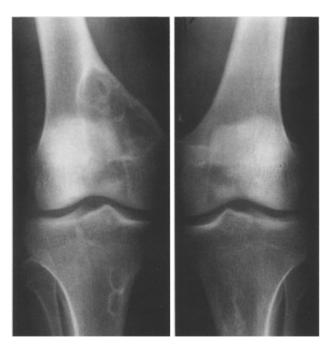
Anteroposterior (AP) radiograph of both knees demonstrates typical multiple skeletal fibroxanthomas – eccentric lytic lesions that are well-defined, have sclerotic margins of variable thickness, and are located in the metadiaphyseal regions of long bones of the lower extremities. There is a large fibroxanthoma in the distal right femur and relatively symmetric fibroxanthomas in the proximal contralateral tibia
